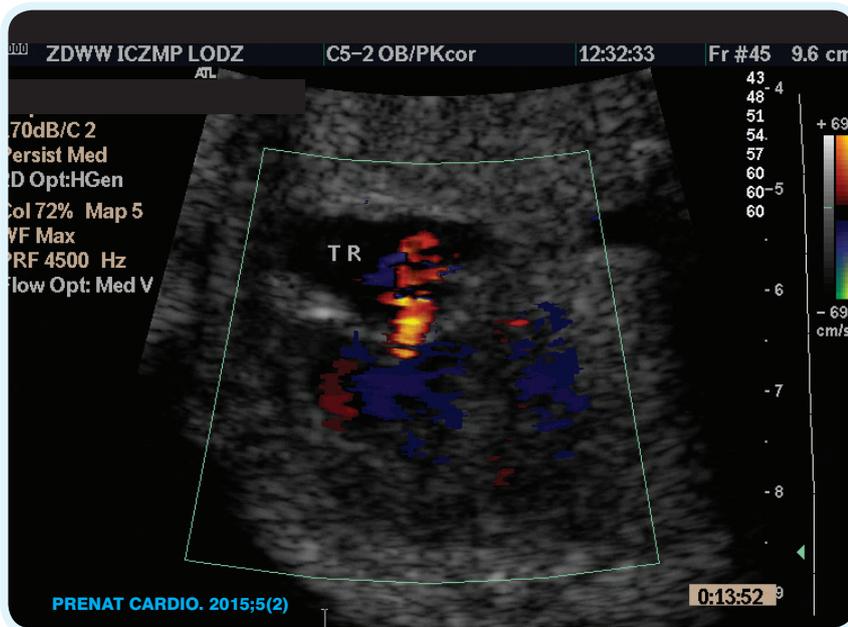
Color doppler assesment of tricuspid regurgitation in fetus in 27 week of pregnancy.
